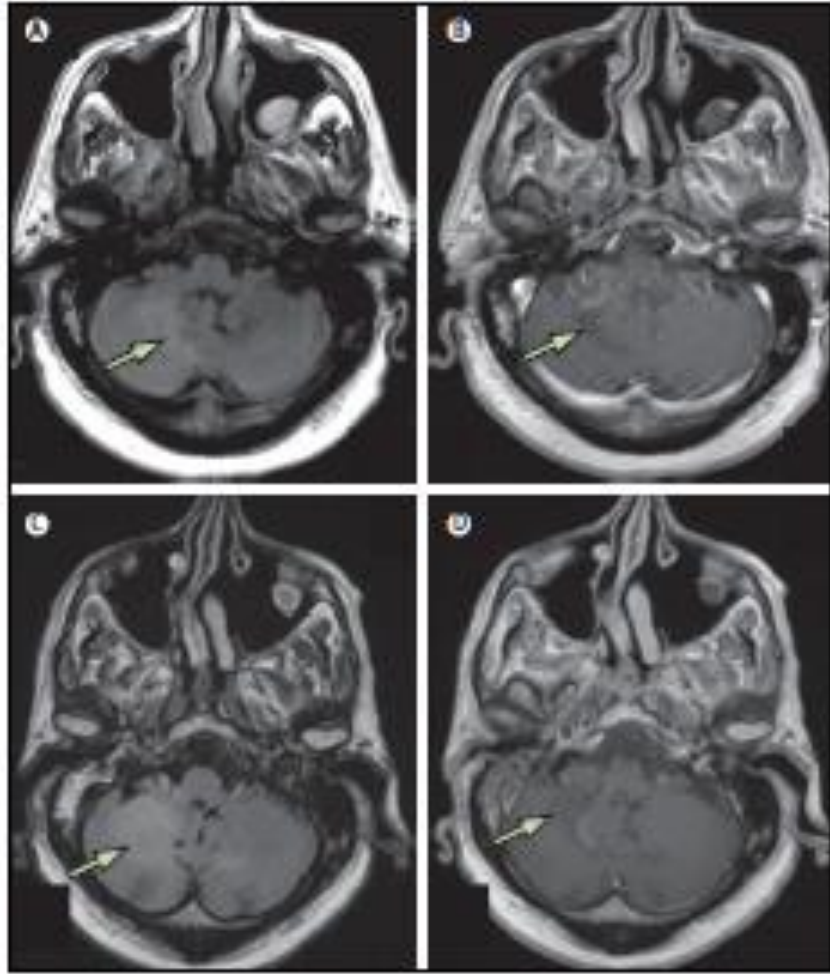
Cerebellar lesions in a patient with PML via MRI: An MRI scan of a lymphocytic leukaemia patient with classic PML. The patient was identified as JCPyV positive via PCR detection of JCPyV in the CSF. Lesions (arrows) were identified by fluid attenuated inversion recovery (FLAIR) (Fig 4A and 4C) and T1-weighted MRI (Fig 4B and 4D) (230).
